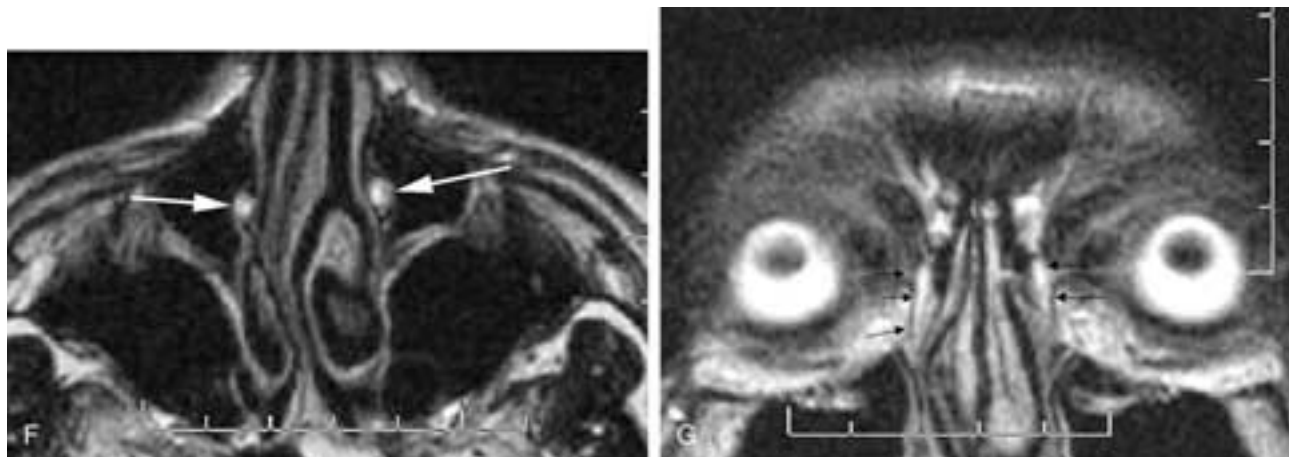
Continued.* F and G, Second patient. Topical saline used as contrast medium. One or 2 drops per minute instilled into the conjunctival sac for 4 to 5 minutes prior to scanning may better demonstrate the lumen of the NLDS (arrows) on axial (F) and coronal (G) T2-weighted sequences. The saline flows more quickly through the drainage system than topical gadolinium, especially if the gadolinium is partially diluted with artificial tear drops.
